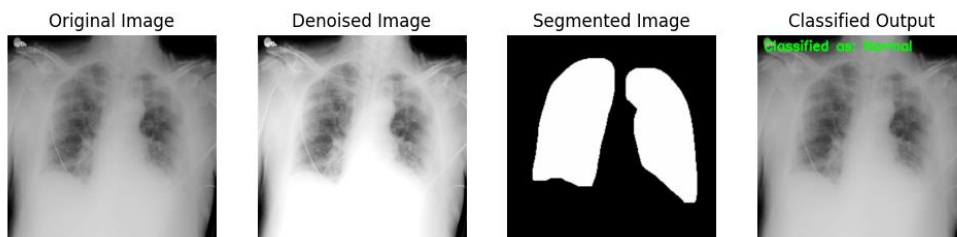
Predicted Outcome on CXR as Non-COVID-19 by Proposed CT-CXR-Net.
